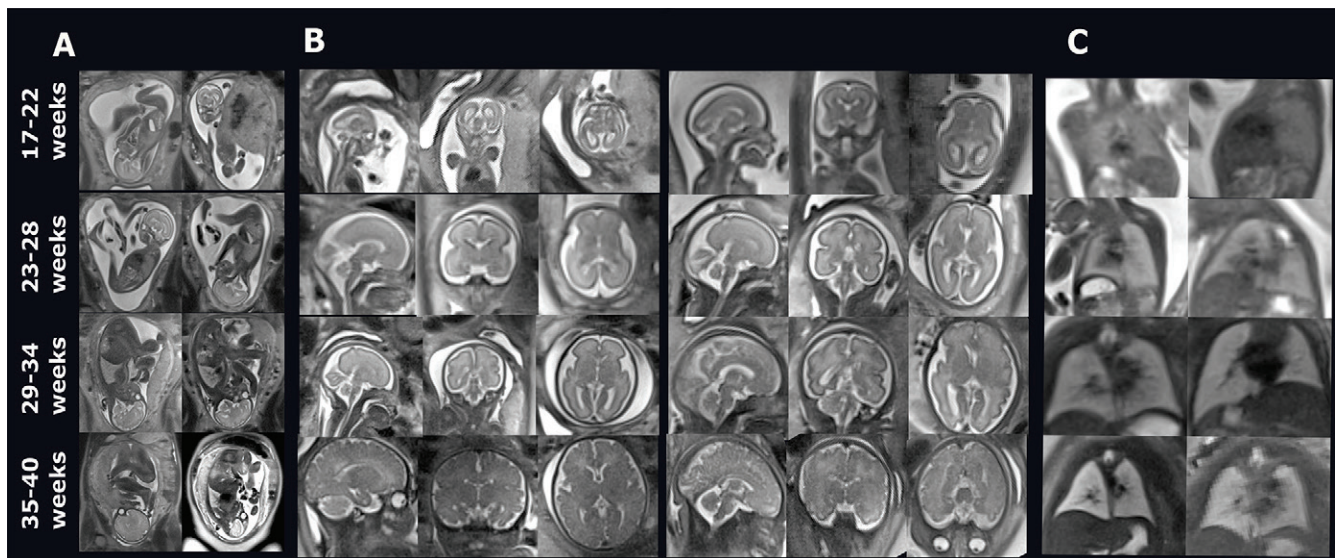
Images show fetal T2-weighted fast-spin-echo 0.55-T MRI scans at various gestational ages. (A) Miduterine coronal anatomic views from eight representative healthy pregnant participants (scans in control participants); (B) planned brain views in sagittal, coronal, and axial orientation from eight representative healthy pregnant participants (scans in control participants); and (C) lung views from eight representative healthy pregnant participants (scans in control participants). The scans are shown in four gestational age ranges.
